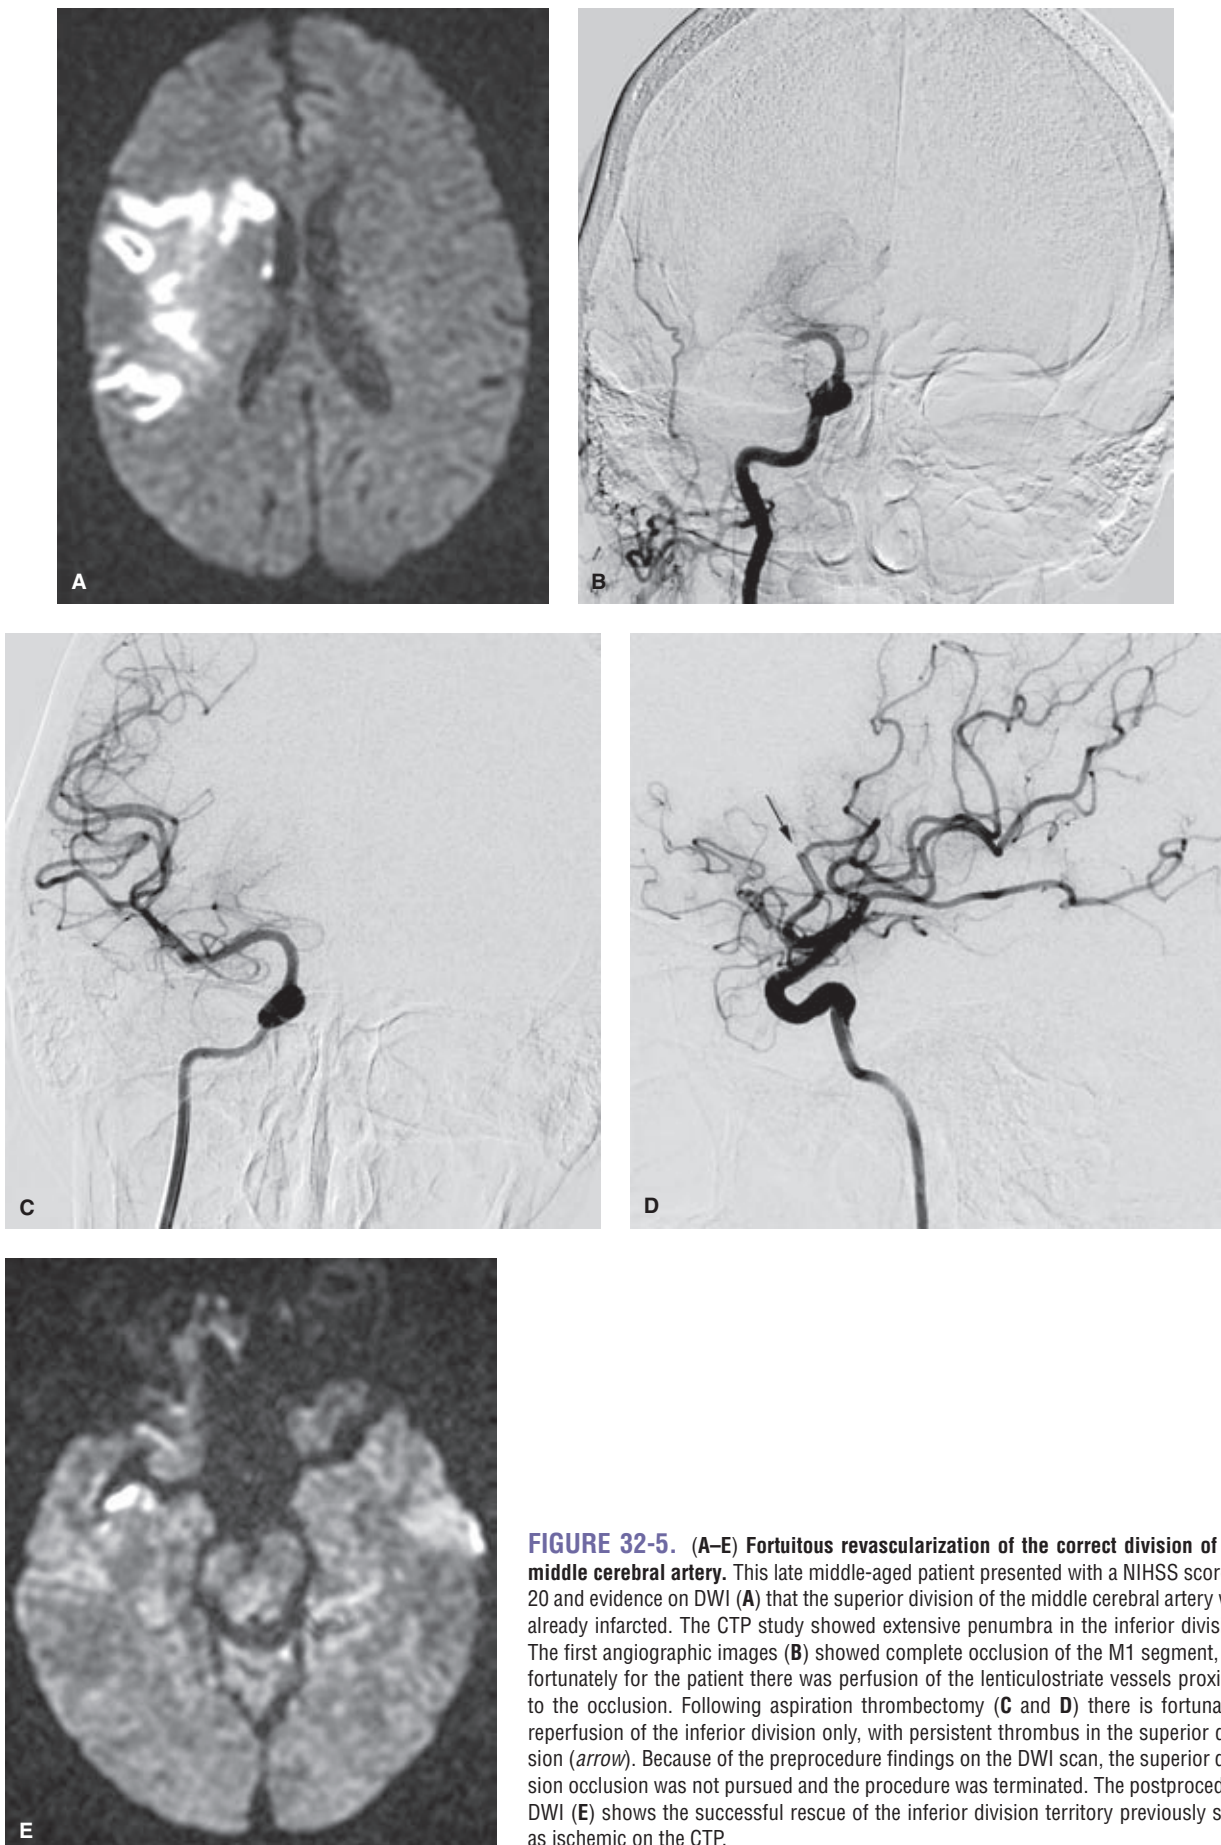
(A–E) Fortuitous revascularization of the correct division of the middle cerebral artery. This late middle-aged patient presented with a NIHSS score of 20 and evidence on DWI (A) that the superior division of the middle cerebral artery was already infarcted. The CTP study showed extensive penumbra in the inferior division. The first angiographic images (B) showed complete occlusion of the M1 segment, but fortunately for the patient there was perfusion of the lenticulostriate vessels proximal to the occlusion. Following aspiration thrombectomy (C and D) there is fortunately reperfusion of the inferior division only, with persistent thrombus in the superior division (*arrow*). Because of the preprocedure findings on the DWI scan, the superior division occlusion was not pursued and the procedure was terminated. The postprocedure DWI (E) shows the successful rescue of the inferior division territory previously seen as ischemic on the CTP.
